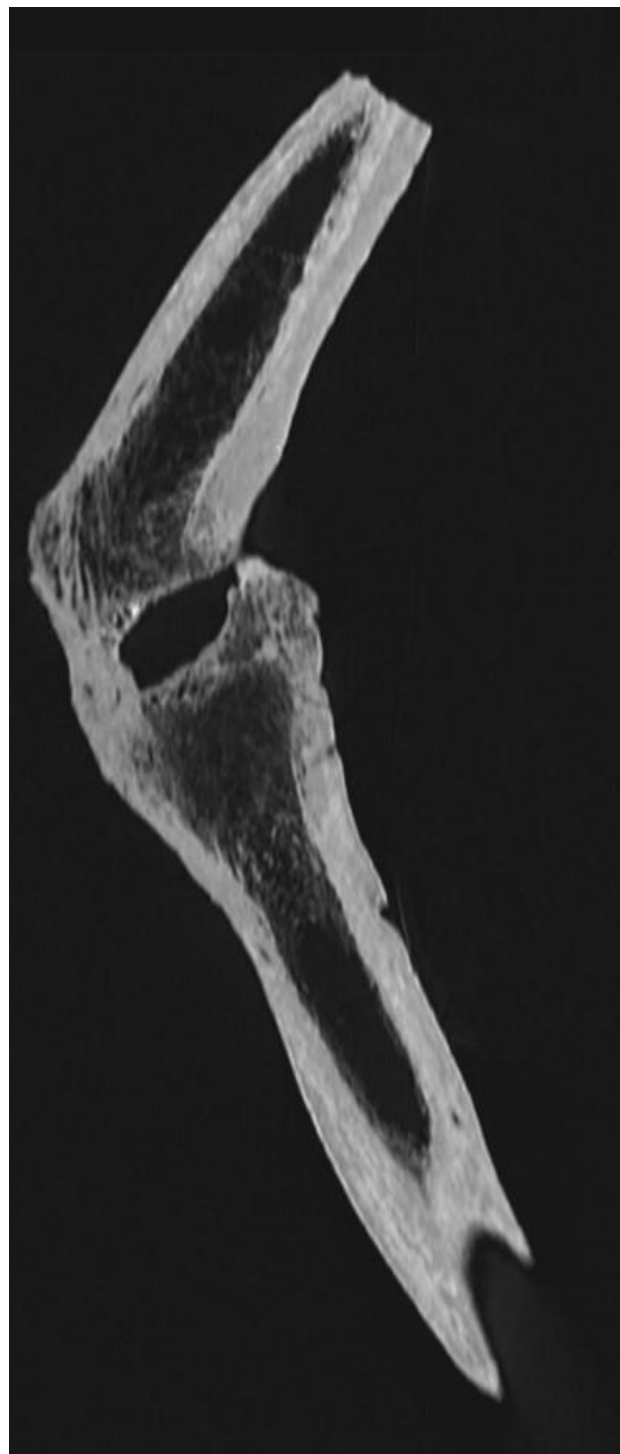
Part of the upper and lower right leg (femur and tibia), completely fused CT imaging
